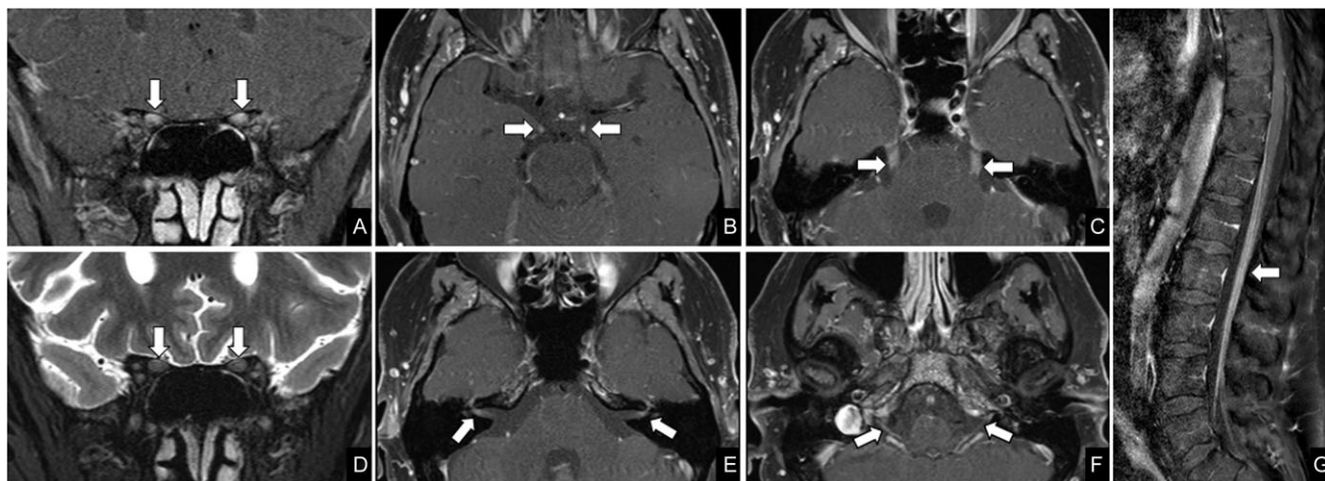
MRI of the brain, orbit and lumbar spine. Coronal post-gadolinium T1-weighted Turbo-Spin-Echo (TSE) with fat saturation (A) and coronal T2-weighted TSE (D) of the orbit show abnormal T2 hyperintensity and enhancement of bilateral optic nerves (arrows in A and D). Axial post-gadolinium T1-weighted TSE with fat saturation at the level of the posterior fossa (B, C, E and F) shows diffuse cranial nerve enhancement involving bilateral oculomotor nerves (arrows in B), trigeminal nerves (arrows in C), facial and vestibulocochlear nerve complexes (arrows in E) and vagus nerves (arrows in F). Sagittal post-gadolinium T1-weighted TSE with fat saturation of lumbar spine (G) shows diffuse smooth thickening and enhancement of the cauda equina nerve roots (arrow in G).
